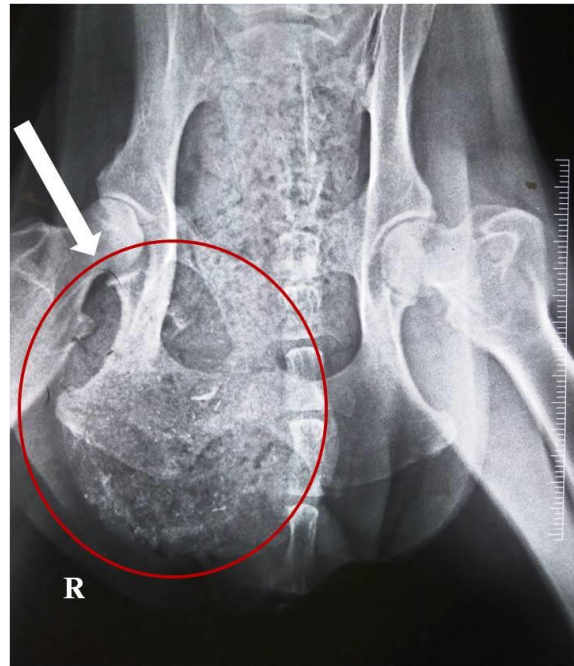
Plain radiograph (ventro-dorsal projection) showing fecal material and gas-filled sac in the right perineal region (red circle)
